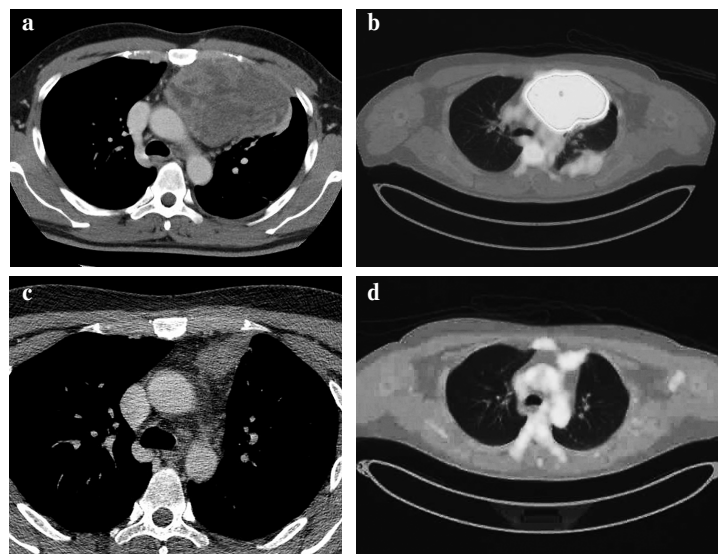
Changes in computed tomography (CT) and fluorodeoxyglucose positron emission tomography (FDG-PET) before and after induction chemotherapy
